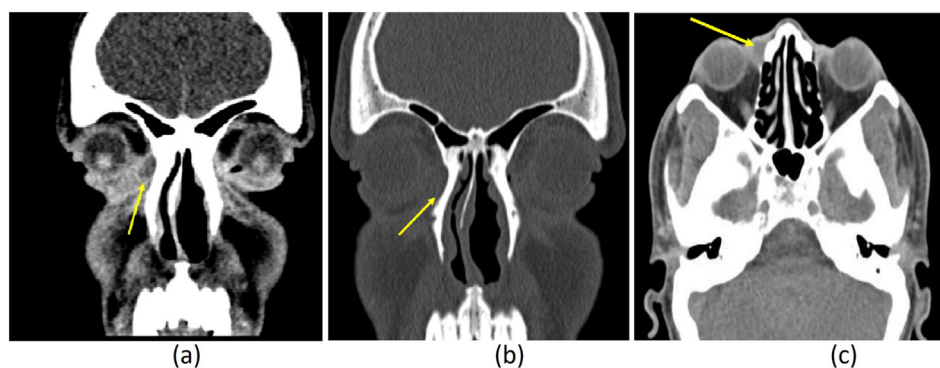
CT cuts (a), (b), (c) showing soft tissue window with enhanced hypodense lesion in right lacrimal region.
